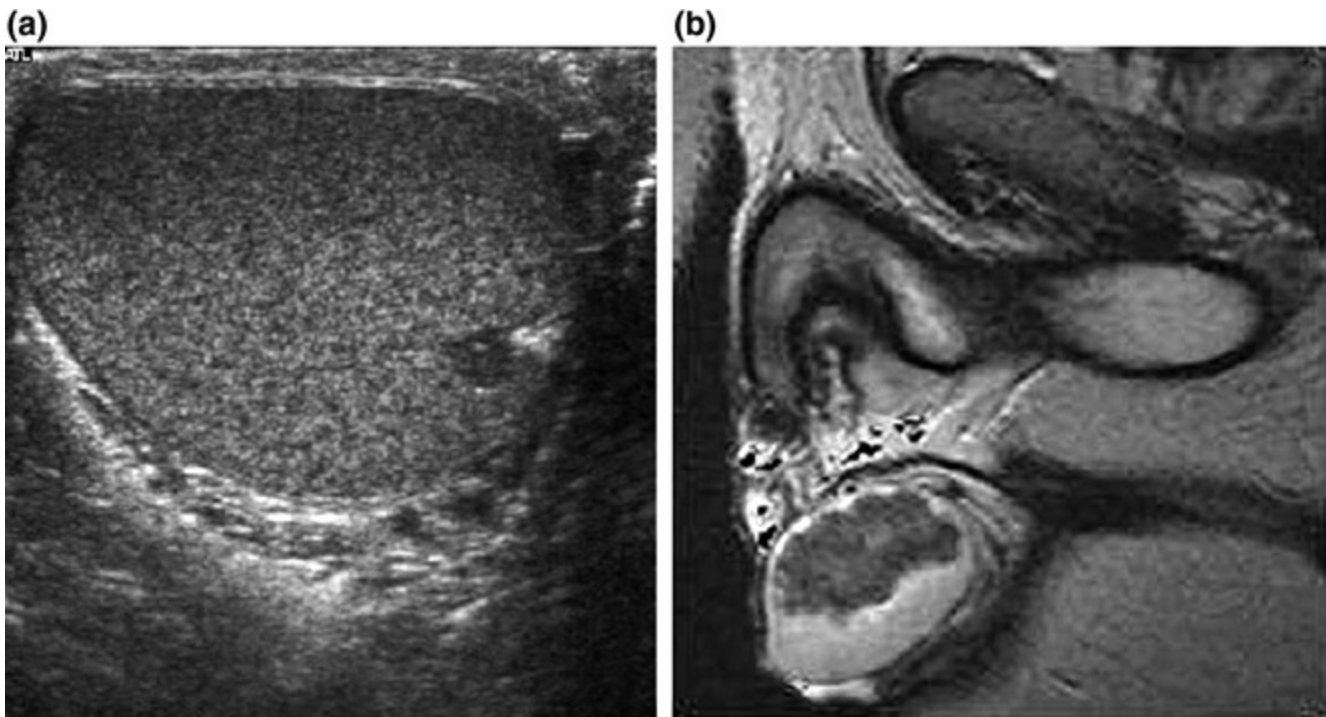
a Scrotal ultrasound of a 13-year-old male CAH patient showing a mostly hypoechoic rounded lesion in the left testis near the rete testis. b T2-weighted MR image of long-standing bilateral testicular adrenal rest tumor. Note that heterogeneous low-signal-intensity tumors are displaced surrounding high-signal normal testicular tissue. From Claahsen-van der Grinten et al. [22] (Open Access)
